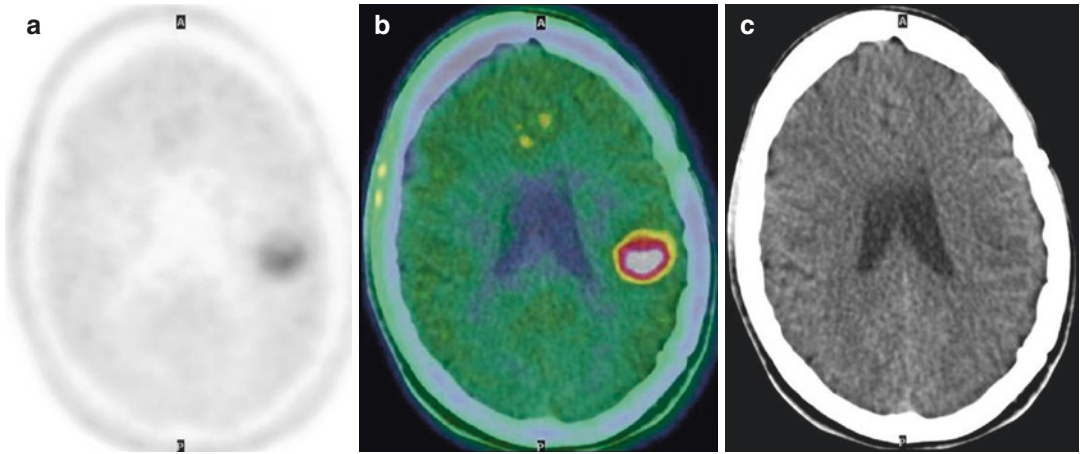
In a patient with glioma, axial ^{18}F -DOPA PET (a) and PET/CT (b) views show intense uptake in the lesion in left parietal region, with mild surrounding edema in the corresponding CT view (c)
